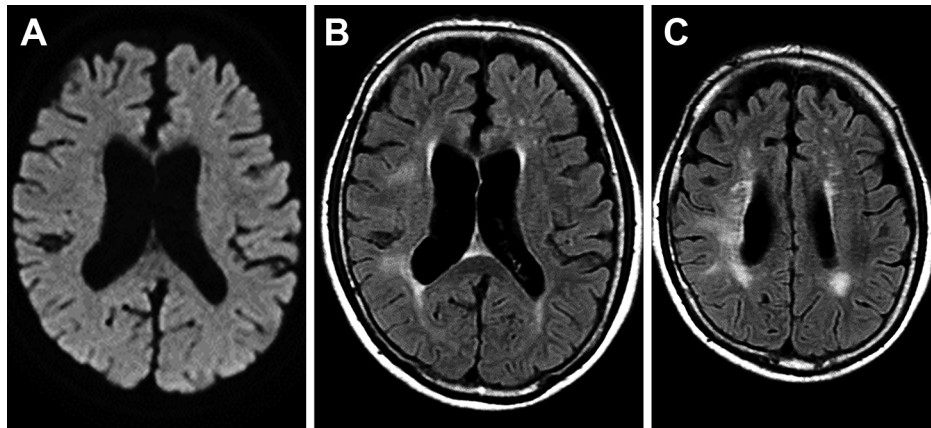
Follow-up magnetic resonance imaging 2 weeks after admission.
